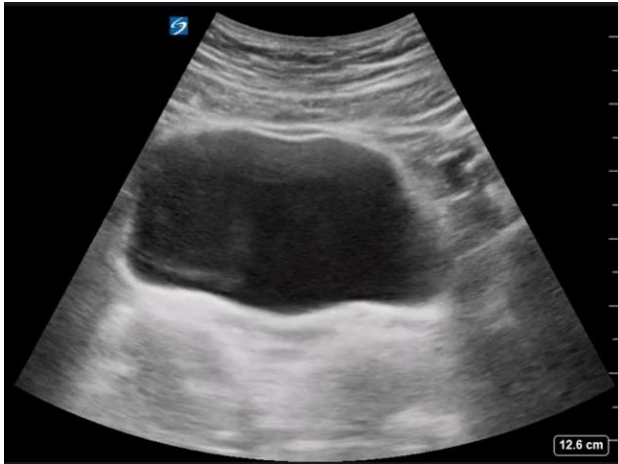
Suprapubic ultrasound through the bladder in transverse orientation with no free fluid visualized⁴.
